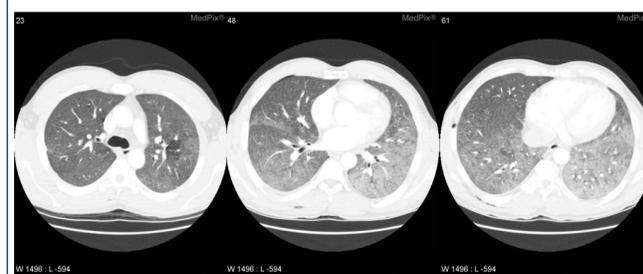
Chest CT shows diffuse ground glass attenuation greater at lung bases with a few nodular opacities.
